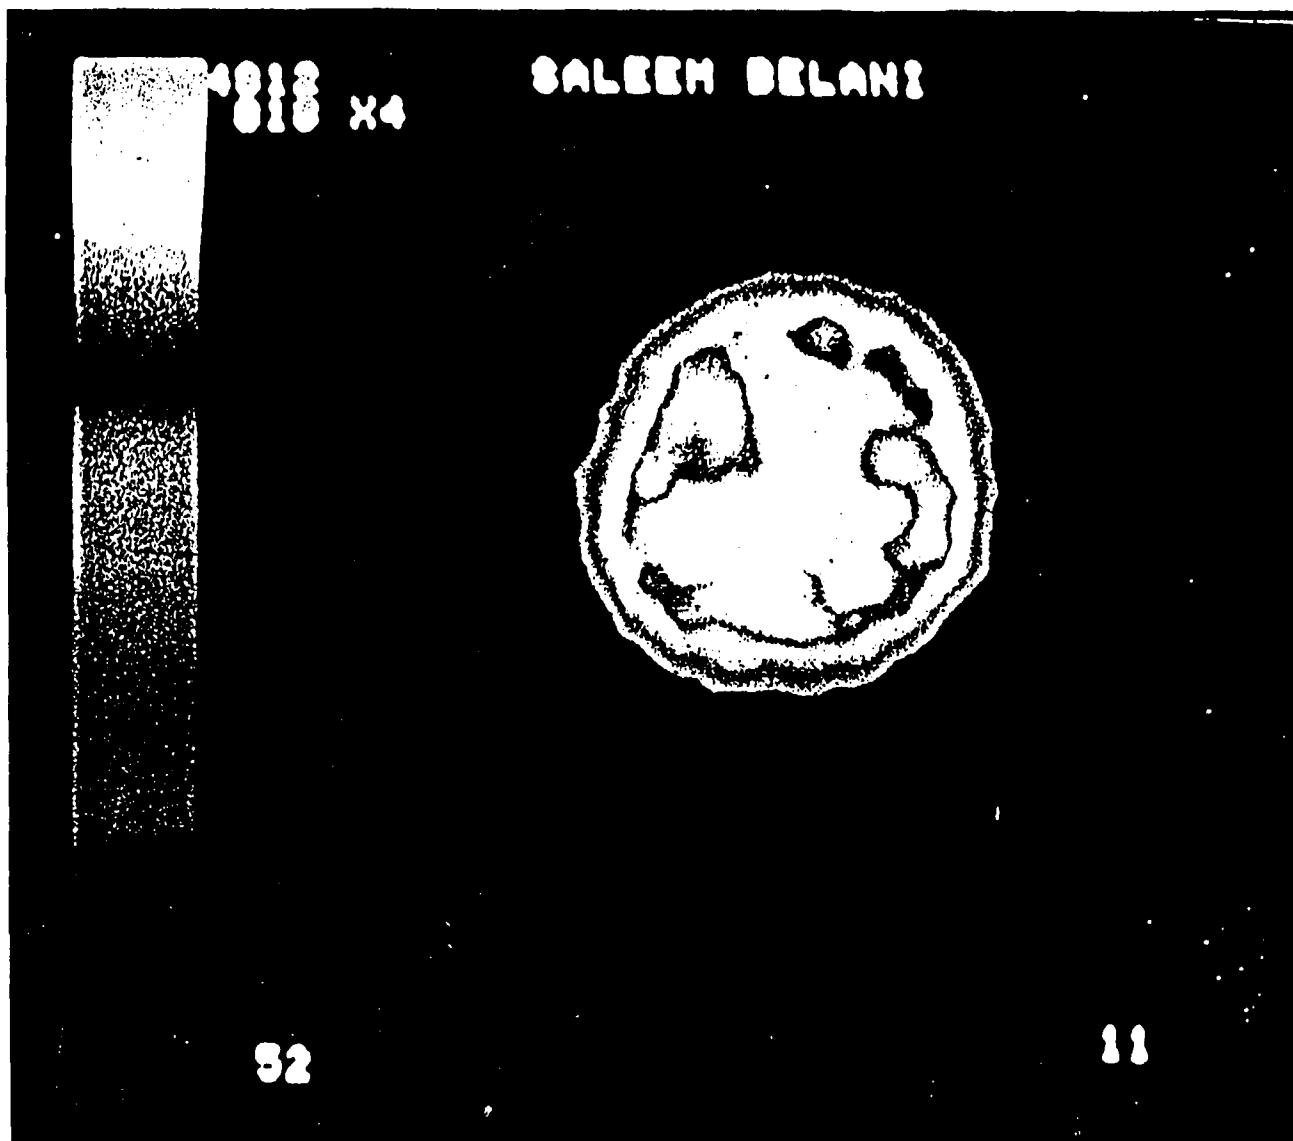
$^{99}\text{Tc}^m$ HMPAO SPECT study showing diminished perfusion in the region of internal capsule on the left-side. CT scan was normal. Patient had sudden onset right sided hemiplegia.
